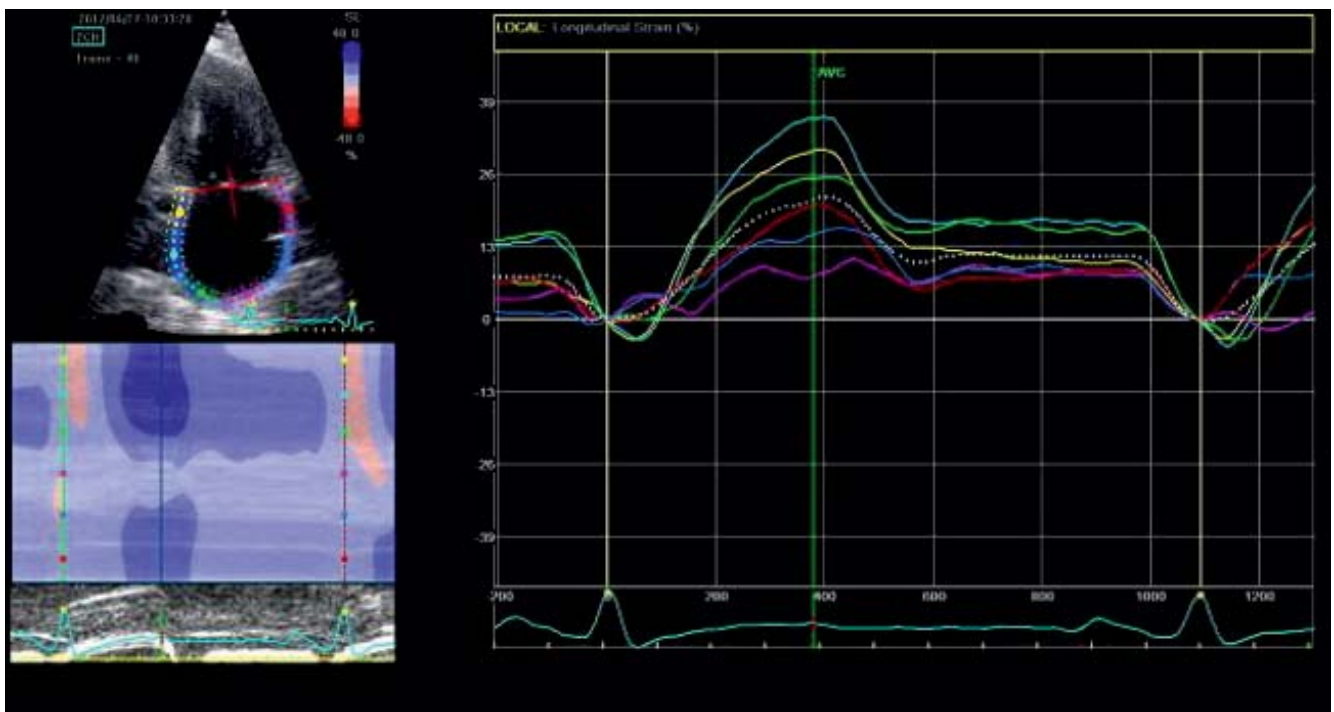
Assessing left atrial strain in apical 2c view.
